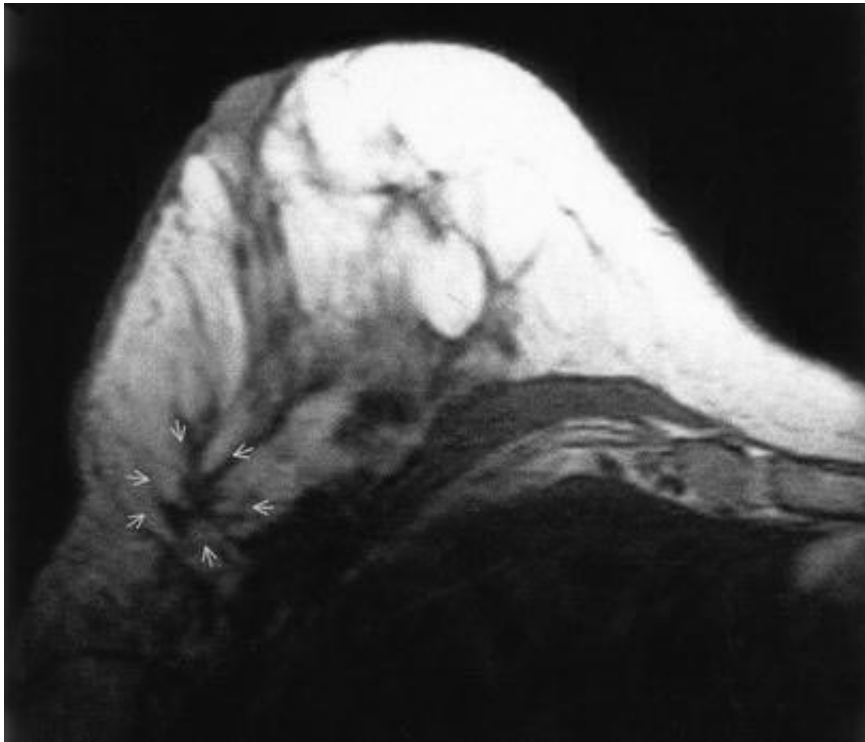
Contrast-enhanced transverse T1-weighted MR image 1 day after laser-induced thermotherapy (LITT). There is no residual contrast-enhancing tumor visible (*arrows*). In the former localization of the tumor a necrosis with a rim of enhancement is shown
